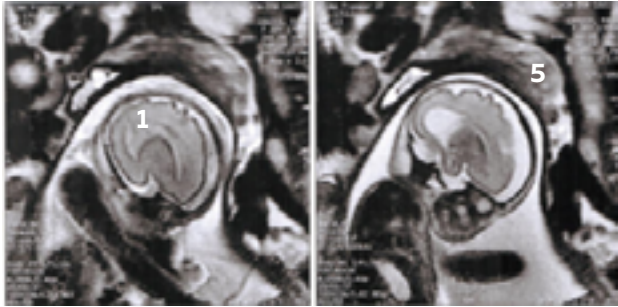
MRI : Mid-sagittal section of the brain : Complete agenesis of the corpus callosum and cervical cystic hygroma (5)
